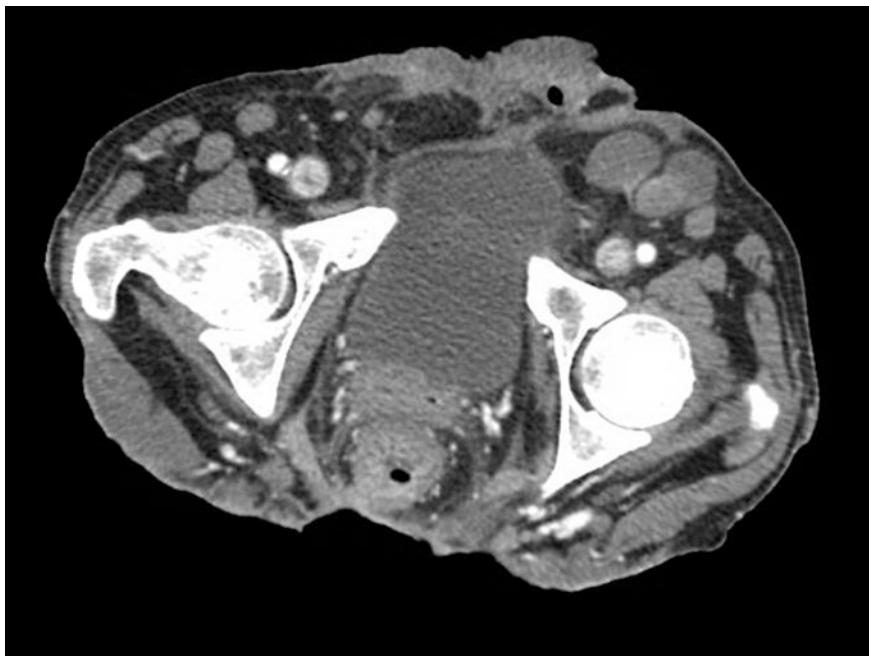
Preoperative CT scan of the pelvis in a 54-year old woman with multifocal squamous cell carcinoma of the perineum arising in a background of hidradenitis suppurativa. Note the left groin lymphadenopathy
